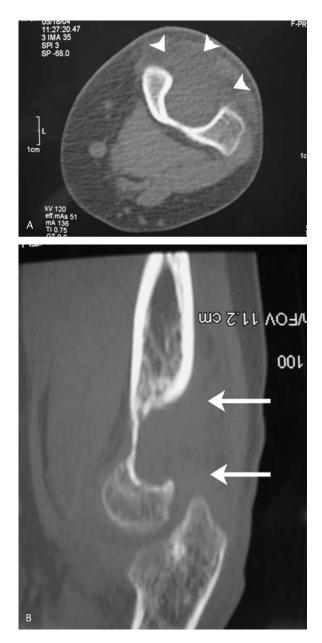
(A) Axial CT image demonstrates a mass with soft tissue attenuation (arrowheads) noted extending posteriorly from the olecranon fossa. (B) On the sagittally reconstructed CT image, the mass (arrows) appears to be remodeling and deepening the olecranon fossa. There is no evidence of periosteal reaction or bony destruction.
